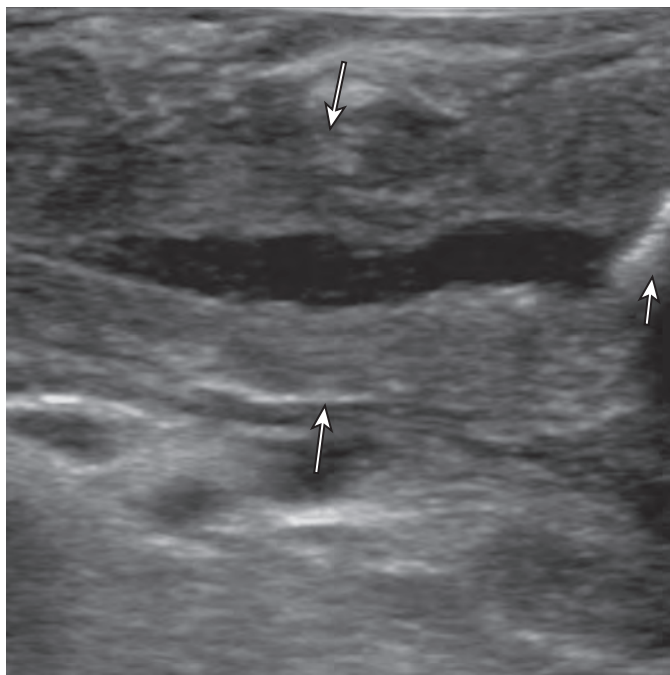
Intraoperative ultrasound of the pancreas for localization of the pancreatic duct before decompressive surgery. The pancreas is well visualized with intraoperative sonography (long arrows). Note the dilated pancreatic duct, measuring 6 mm in diameter. The needle tip is seen entering the pancreatic duct (short arrow).
